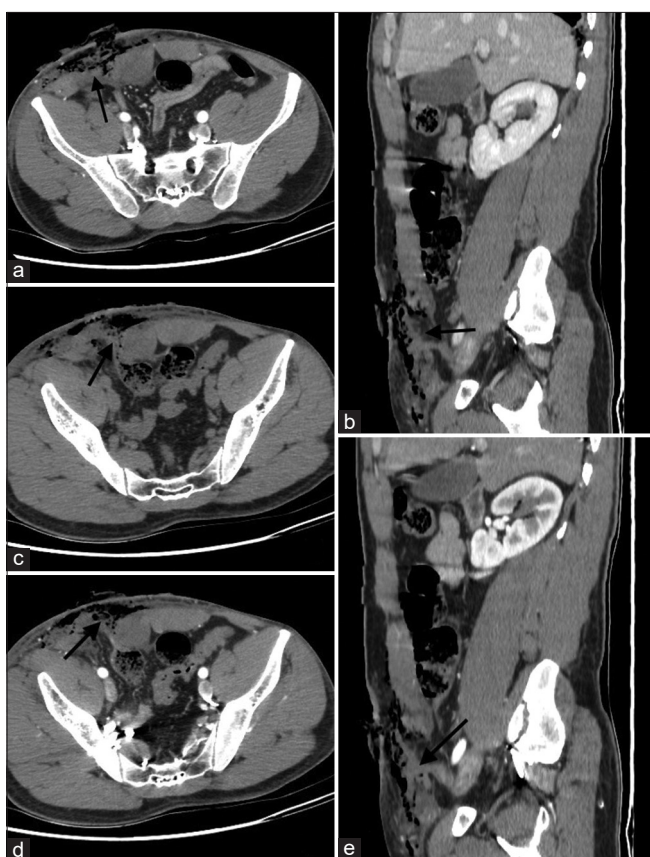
(a and b) Right rectus abdominis defect (black arrow) and defect in skin and subcutaneous tissue with mottled air foci and free fluid in subcutaneous plane seen on (a) Computed tomography (CT) arterial phase axial image (b) CT venous phase sagittal image. (c-e) Prolapse of a segment of the distal ileal loop through rectus defect showing discontinuous wall. (c) CT plain image (d) CT arterial phase axial and (e) sagittal images showing no wall enhancement suggestive of evisceration and perforation of bowel with gangrene.
